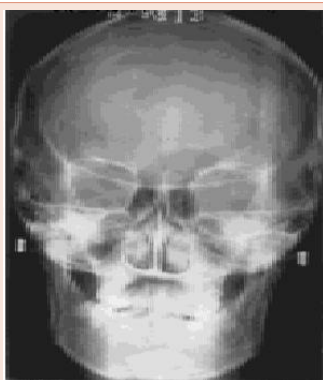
The A-P cephalometric radiographs of right hemifacial microsomia.
